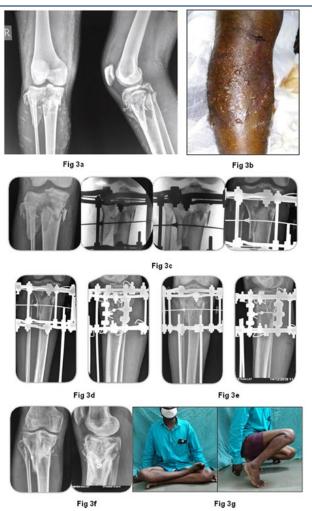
25-year-old male, Road Traffic Accident a) Radiograph showing Schatzker type VI intra articular proximal tibia fracture; b) Skin condition showing hemorrhagic blisters c) Intra Operative X ray images showing Metaphysical reduction with the use of olive wires; d) Post-Operative radiographs of tibia AP and Lat views; e) 3 months Post-Operative radiographs showing good alignment and progressive fracture union; f) Knee radiograph 6 months after ring removal showing good union at fracture site and intra articular congruity; g) Excellent functional outcome 6 months after ring removal.
